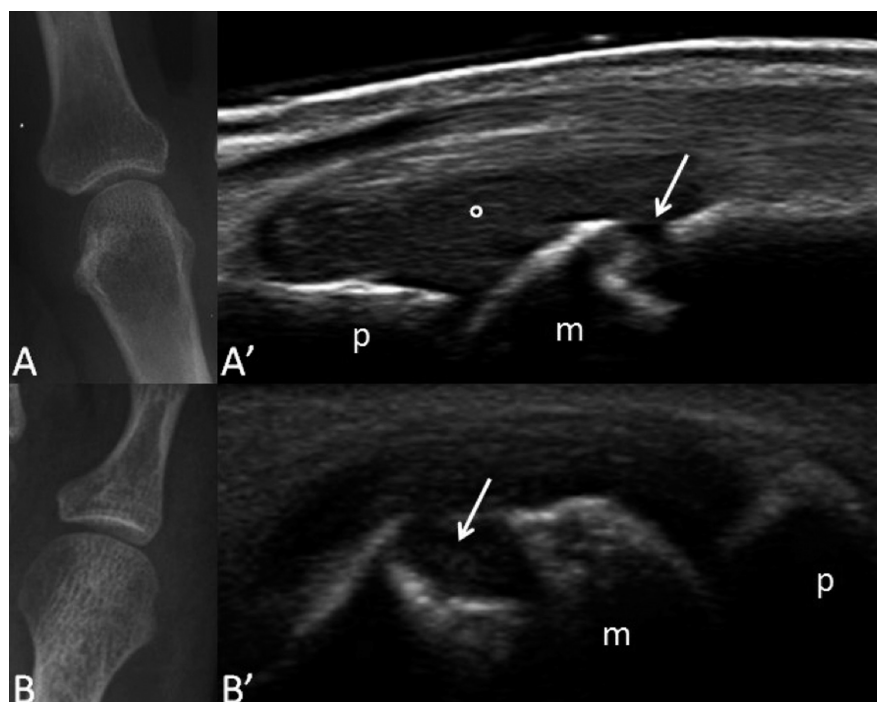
A. Conventional radiography in postero-anterior view showing the second metacarpophalangeal joint. No alterations indicative of bone erosions are appreciable. The respective ultrasound examination shows a clear erosion (arrow) at the metacarpal head level. Moreover, it is possible to observe a proliferative joint cavity widening (circle) (A').
